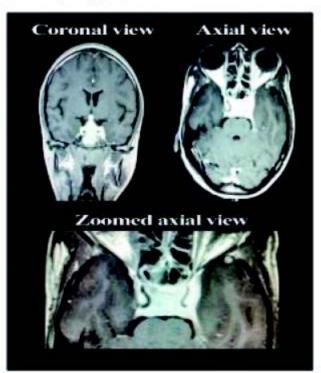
MRI brain with MRA and MRV with contrast
